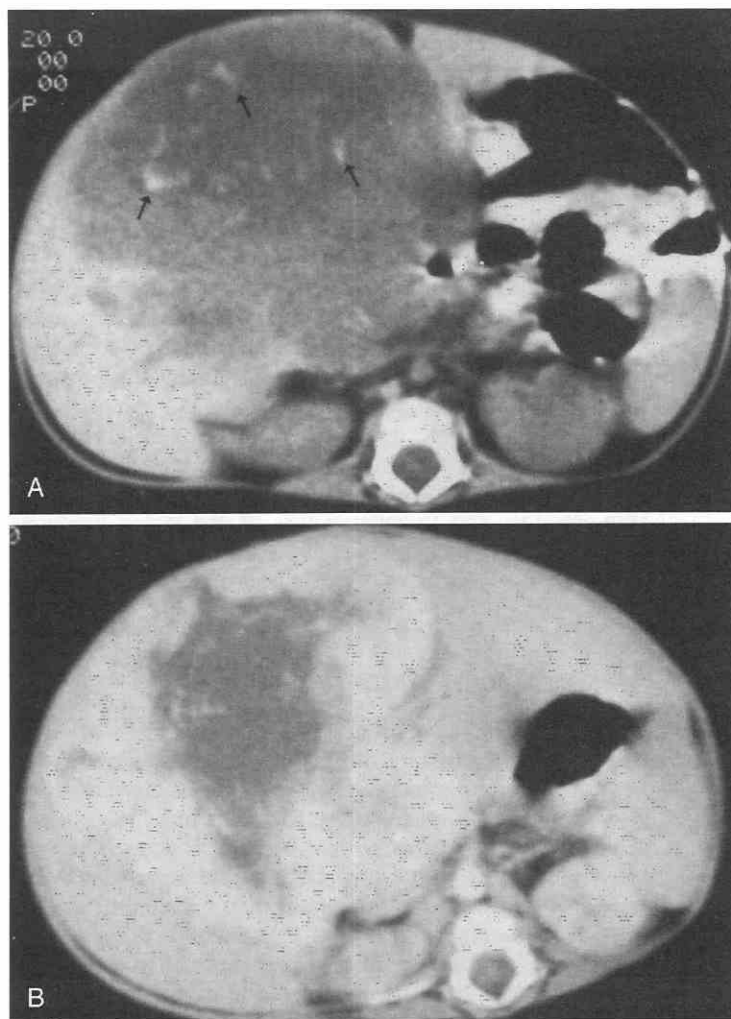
Infantile hemangioendothelioma in a 1-month-old boy. *A*, Unenhanced CT scan shows a large mass of the liver containing calcifications (*arrows*). *B*, Contrast-enhanced CT scan shows the enhancement beginning in the periphery, similar to that seen with hemangioma.
